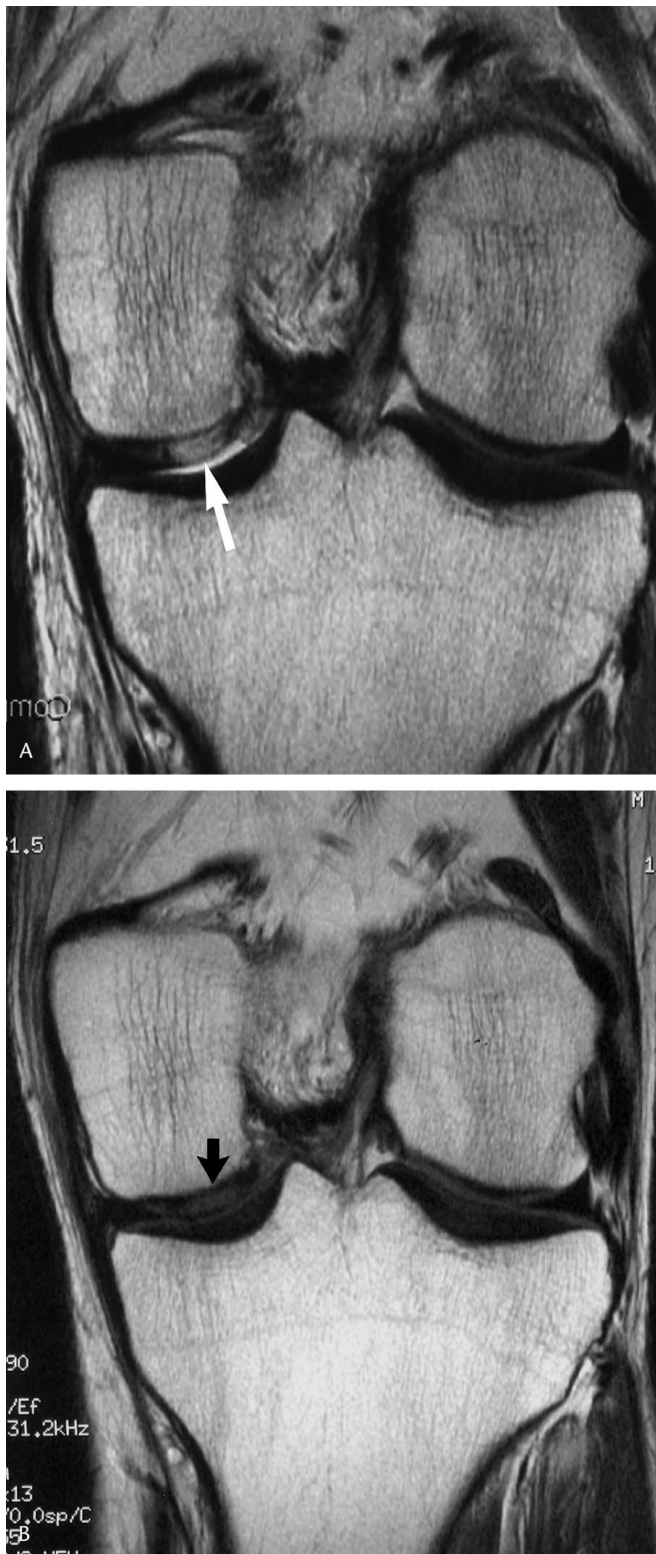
Coronal MRI scans of a 31-year-old man were obtained (A) 6 weeks and (B) 20 months after autologous chondrocyte implantation. Figure 2A shows a hyperintense graft with an intact, hypointense periosteal graft (arrow). Figure 2B, obtained at the same coronal level, shows isointense repair cartilage, with incorporation of the periosteum to the cartilage, such that the periosteal cover is indistinct (arrow).
